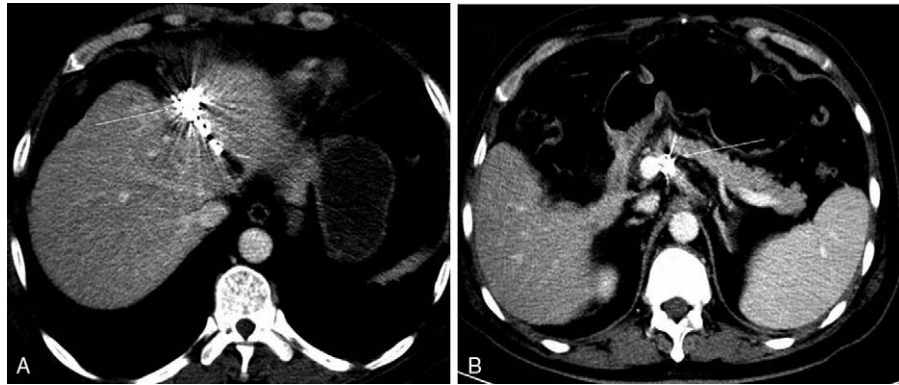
CT images at 15 months after I-125 seed implantation suggested that the tumors were largely reduced (A: hepatic tumor [white arrow], B: pancreatic tumor [white arrow]). CT=computerized tomographic scanning
